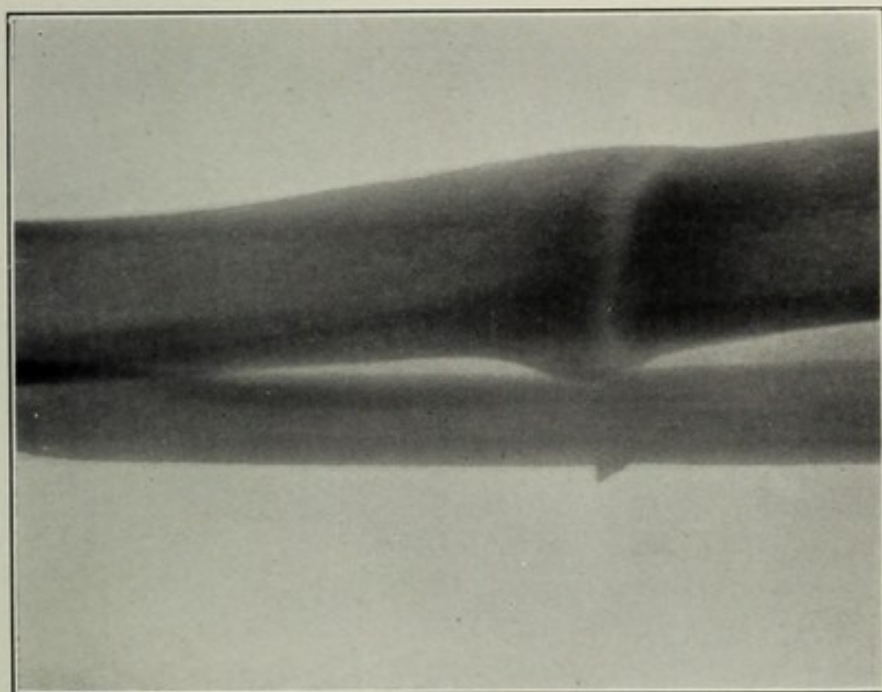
Bony union in fracture of the tibia, 4½ years after the injury, showing translucency to X-rays.*
